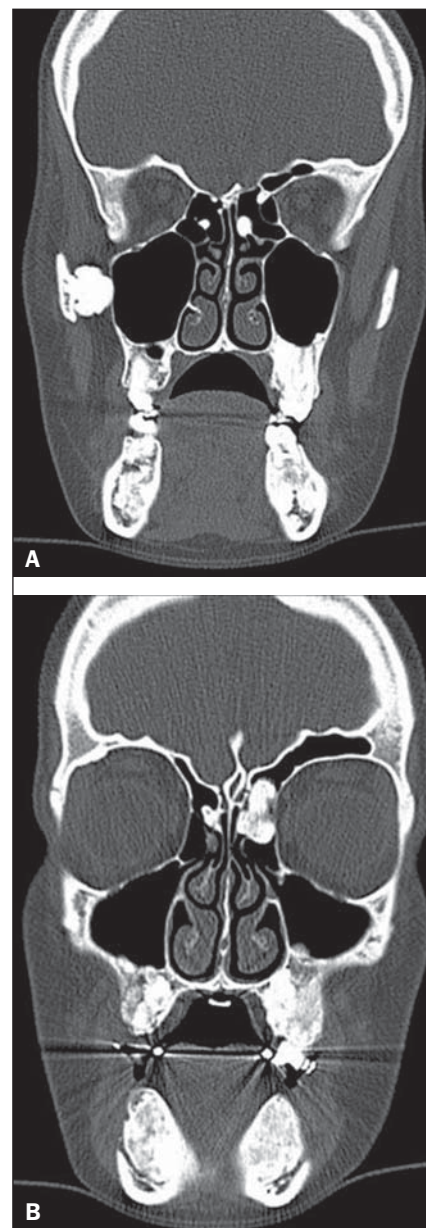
Coronal CT sections, bone window.
